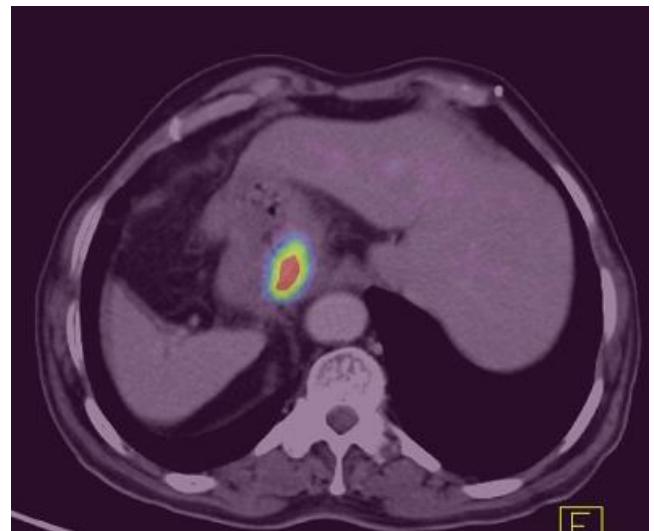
Axial fused F-18 FDG PET/CT positron emission computed tomography-computed tomography (PET /CT) showing hypermatbolic uptake in Gastroesophageal junction carcinoma.
